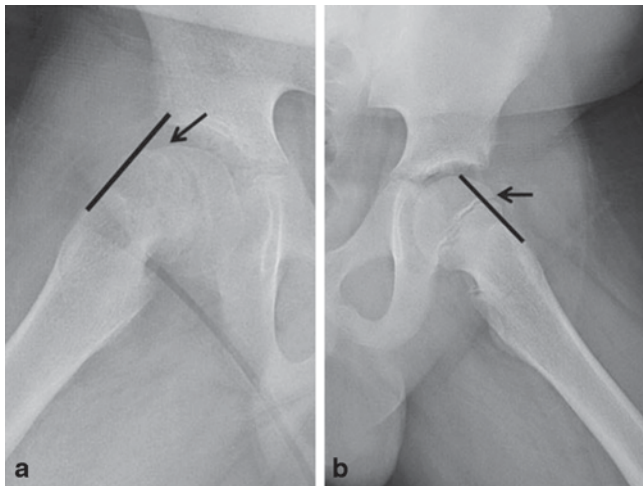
A 13-year-old boy with right hip and knee pain of 2 weeks duration. Radiographs taken for both hips AP and lateral views. Lateral radiograph of the both hips are presented in this figure. Klein's line (the black line) is drawn along the anterior femoral neck and normally (left side) should intersect part of the epiphysis of the proximal femur (an arrow is pointing to the anterior edge of the epiphysis). On the right side (SCFE) the Klein's line does not intersect any part of the epiphysis
